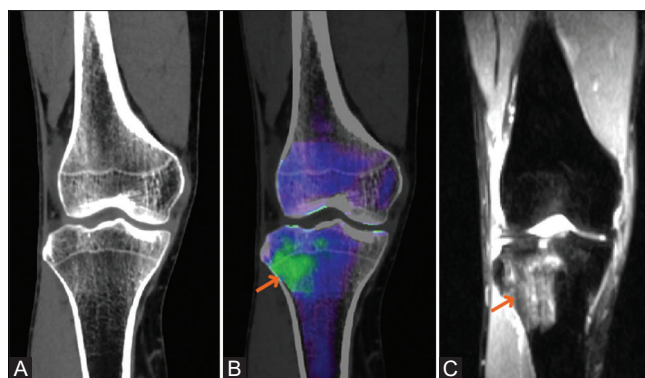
(A-C): (A) Coronal views of a CT image of the right knee joint of a patient with bone marrow edema on the lateral aspect of the proximal tibia. (B) Coronal views of a DE VNCa image of the right knee joint show bone marrow edema (arrows) on the lateral aspect of the proximal tibia. (C) Coronal views of a STIR MR image of the right knee joint show bone marrow edema (arrows) on the lateral aspect of the proximal tibia
